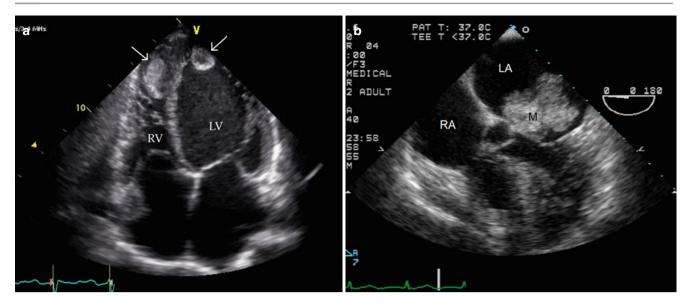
(a) Apical four-chamber view demonstrating thrombi (*arrows*) in the apexes of the right ventricle (*RV*) and left ventricle (*LV*). (b) Transesophageal echo image of a large left atrial myxoma (*M*). *RA*
